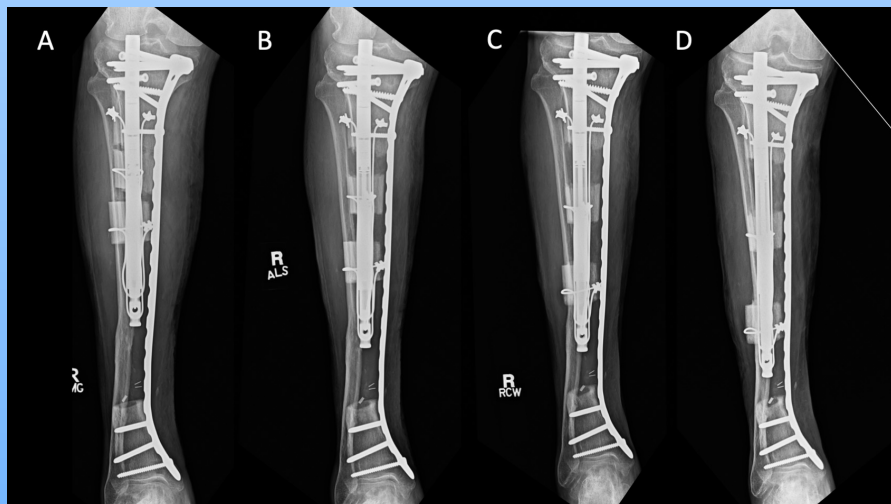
Transport. AP radiographs taken at postop day 14 (A), 35 (B), 52 (C), and 65 (D) demonstrate consistent transport of both segments.
